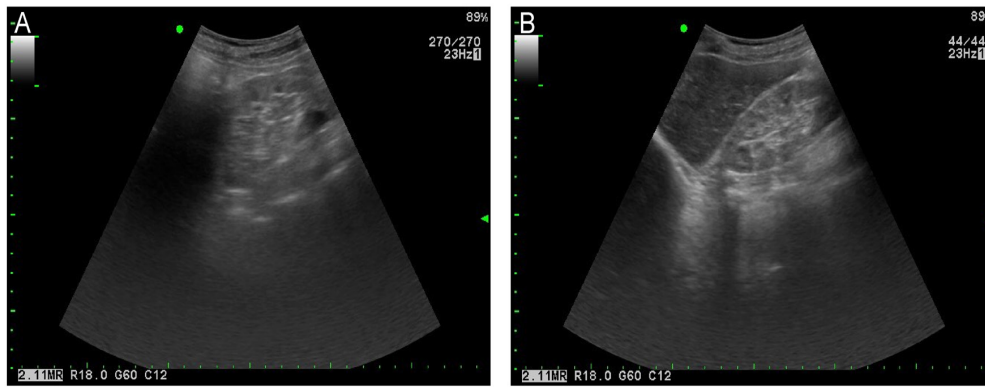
Ultrasound Images of Kidney Parenchymal Change. (A), Left kidney parenchymal change; (B), Right kidney parenchymal change.
